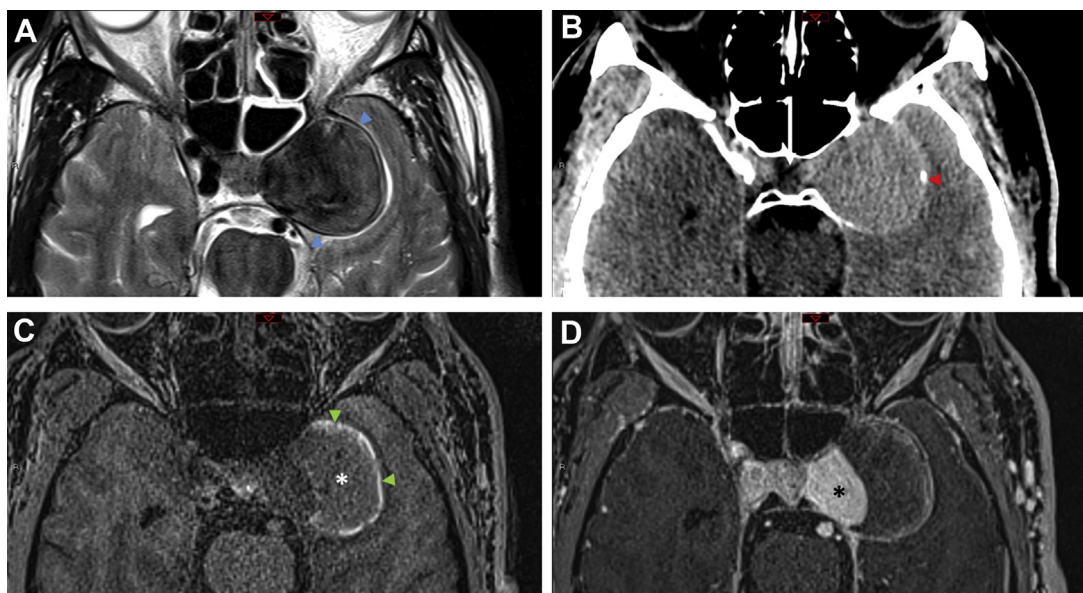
Giant aneurysm. Axial T2-weighted MR image (A), axial noncontrast CT (B), axial noncontrast T1-weighted MR image (C), and axial postcontrast T1-weighted MR image (D) in a 63 year old presenting with left cranial nerve III palsy. The left cavernous carotid artery aneurysm wall demonstrates smooth low signal intensity on T2-weighted images (*blue arrowheads* in A) and peripheral calcification (*red arrowhead* in B). The patent portion of the aneurysm sac shows avid contrast enhancement, which approximates that of other vascular structures (*asterisk* in D). The nonenhancing mural thrombus within the aneurysm sac shows variable signal, with discontinuous peripheral hyperintensity (*green arrowheads* in C) and vague central hypointensity (*asterisk* in C) on T1-weighted images.
